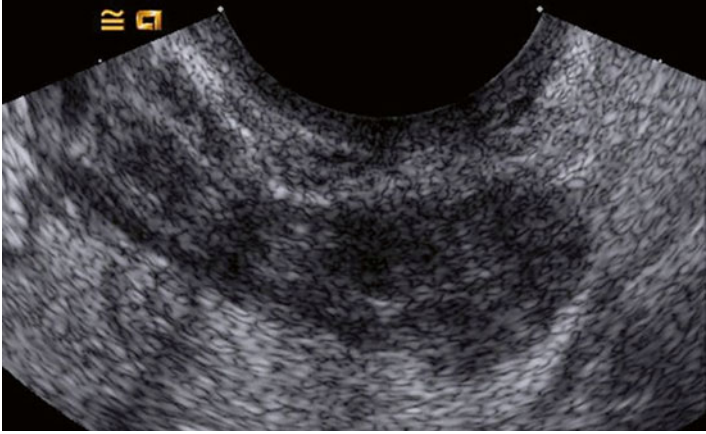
Acute salpingitis by ultrasound, verified by laparoscopy. The sausage-shaped solid structure corresponds to the inflamed tube (Reprinted from Romosan et al. [27], by permission of Oxford University Press and The European Society of Human Reproduction and Embryology)
